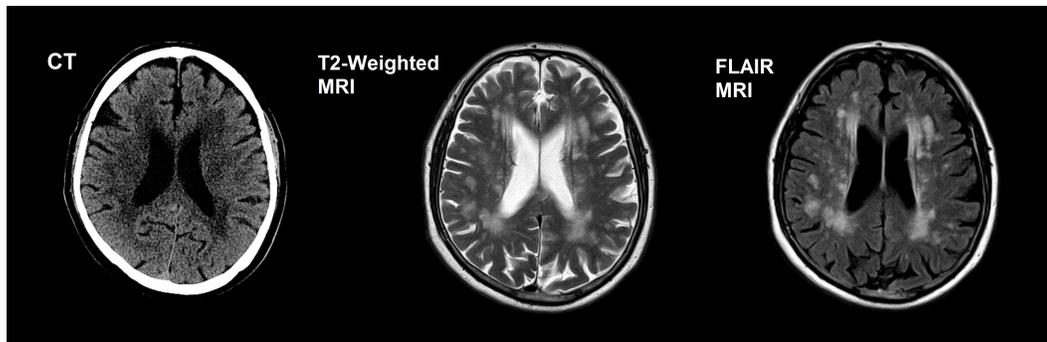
Chronic white matter changes as seen on CT, T2-weighted and FLAIR (Fluid Attenuated Inversion Recovery) MRI.
